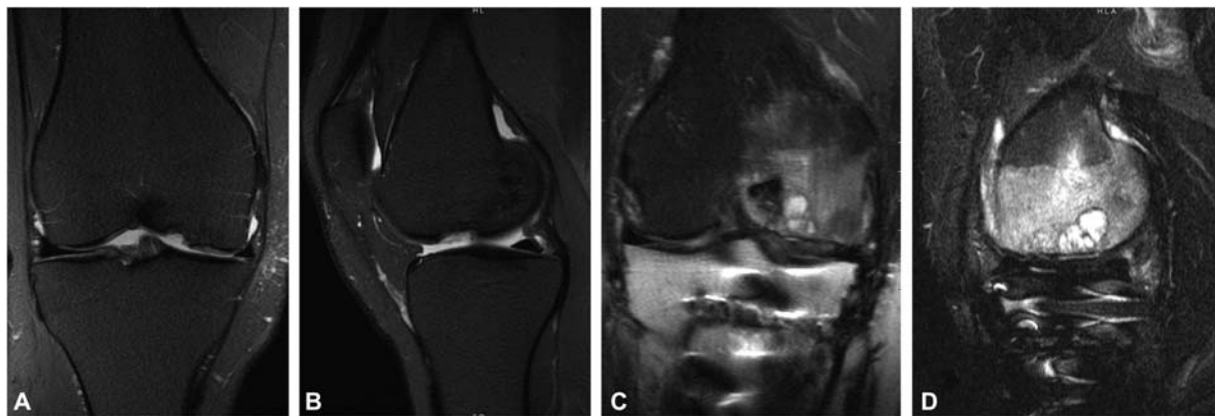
Magnetic resonance imaging of the knee from two different patients with medial femoral condyle cartilage defects. On the left (A and B) is an isolated cartilage defect without surrounding bony edema; on the right (C and D) is a large cartilage defect with underlying subchondral bone cystic changes and extensive bony edema.
